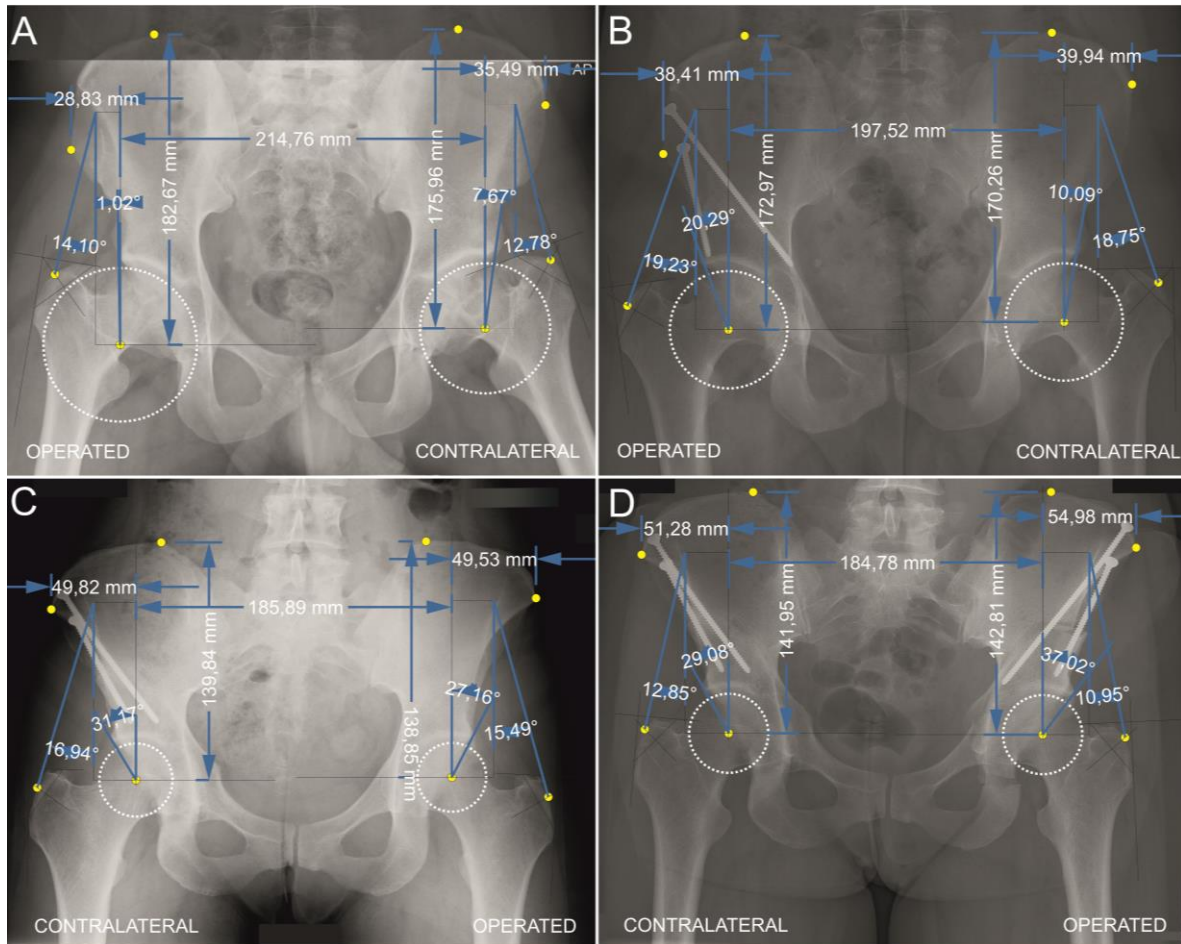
X-Ray scans of two cases of the operation from centre C1 in which the stress on the contralateral side improved most (before and after the operation (A, B)) and in which worsened most (before and after the operation (C, D))
